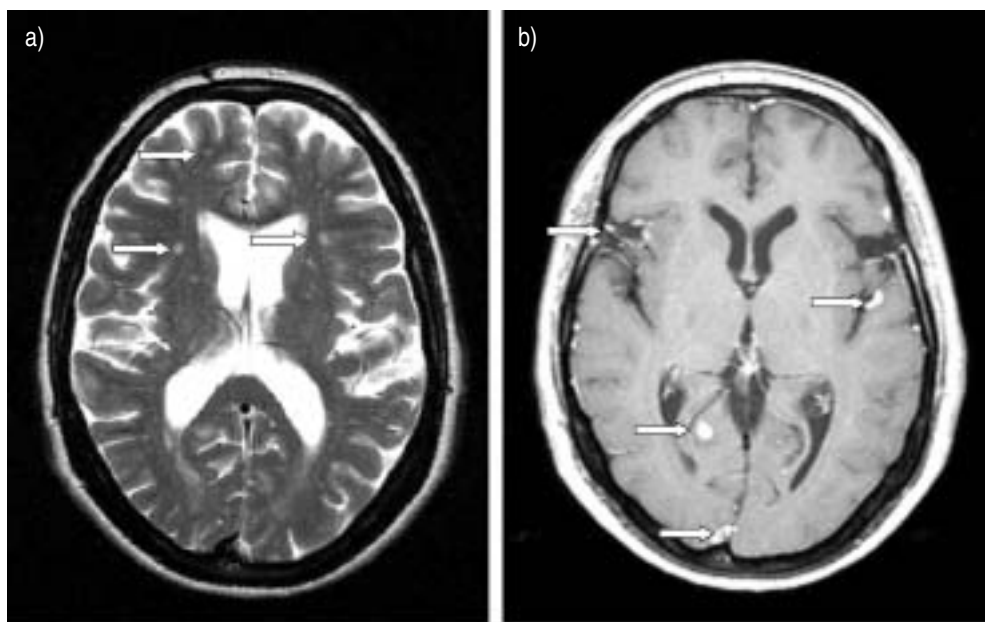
Cerebral magnetic resonance imaging of case A: a) T1-weighted, revealing nonspecific white matter lesions (arrows); and b) gadolinium-enhanced T2-weighted, revealing leptomeningeal-enhancing lesions (arrows).
